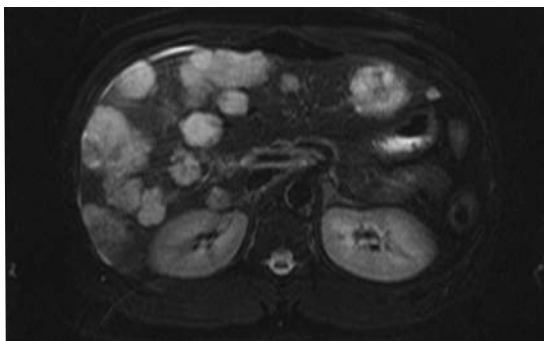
Magnetic resonance imaging shows multiple lesions in the liver.
